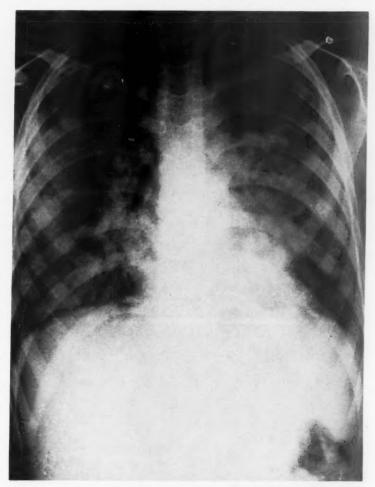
The first admission chest x-ray shows hilar and mediastinal lymphadenopathy and extensive blotchy infiltrates throughout both lungs. Note the air bronchogram.
